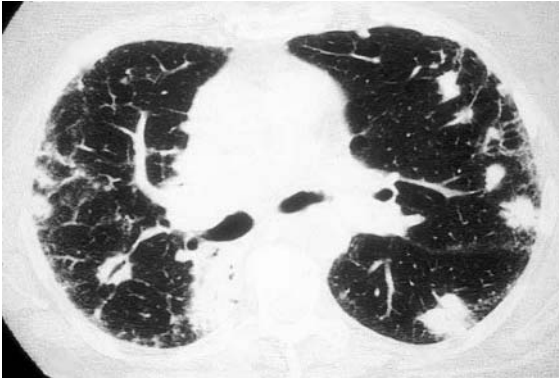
HRCT in a 56-year-old woman with progressive systemic sclerosis and associated lung carcinoma. The HRCT scan shows a bilateral fine reticular pattern in a patchy and subpleural distribution. Multiple peripheral nodules representing multifocal bronchiolo-alveolar cell carcinoma are also seen. Note that an air-bronchogram is visible within some of the nodules.
